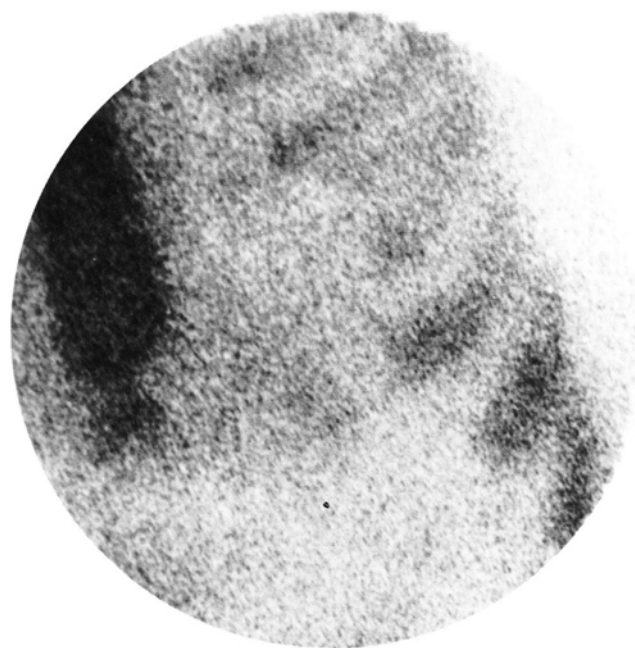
Anterior projection of a normal planar ^{99m}Tc pyrophosphate myocardial scintigram showing no myocardial uptake.
